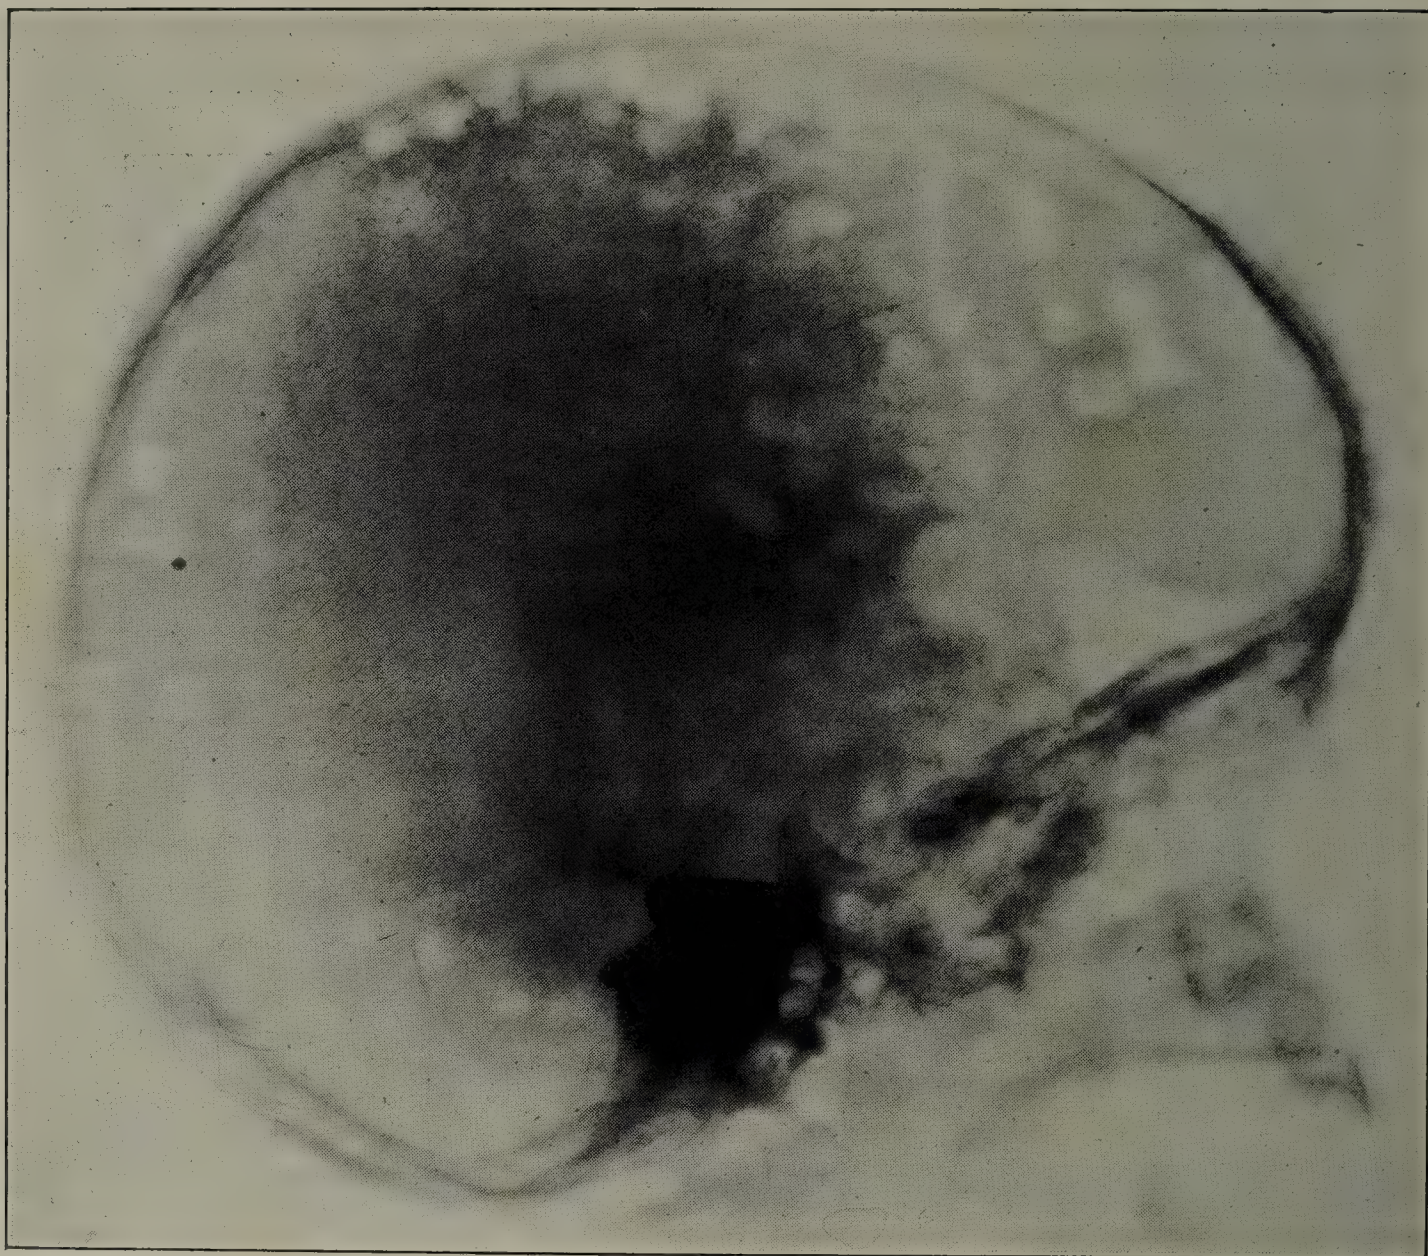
ROENTGENOGRAM OF SKULL IN XANTHOMATOSIS, SHOWING MULTIPLE PUNCHED-OUT AREAS OF RAREFACTION.
